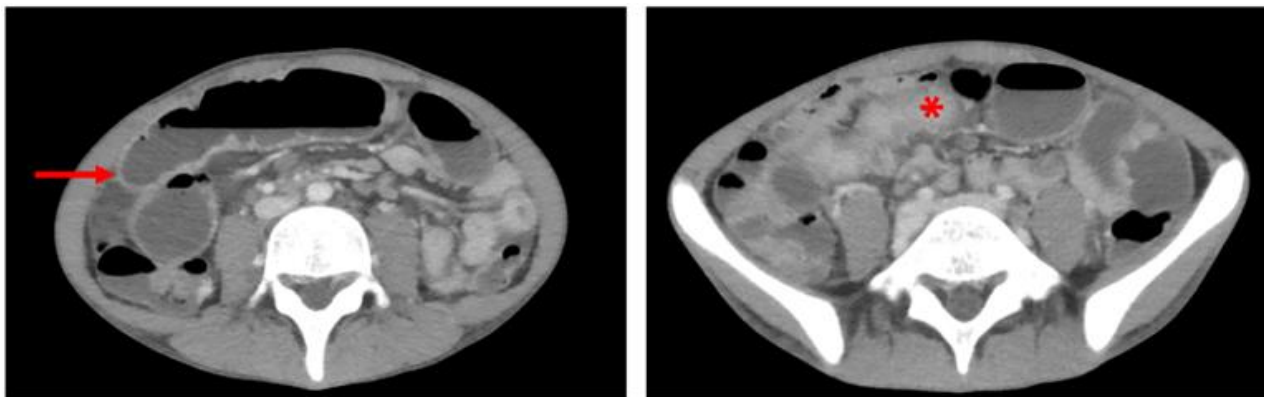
CT abdomen/pelvis (axial view) with 80 cc of Omnipaque 350 intravenous contrast using 3 mm increments obtained 5-months prior to admission. Arrow demonstrates diffusely thickened, dilated small bowel with air-fluid levels. Asterisk shows luminal narrowing of the distal ileum.
